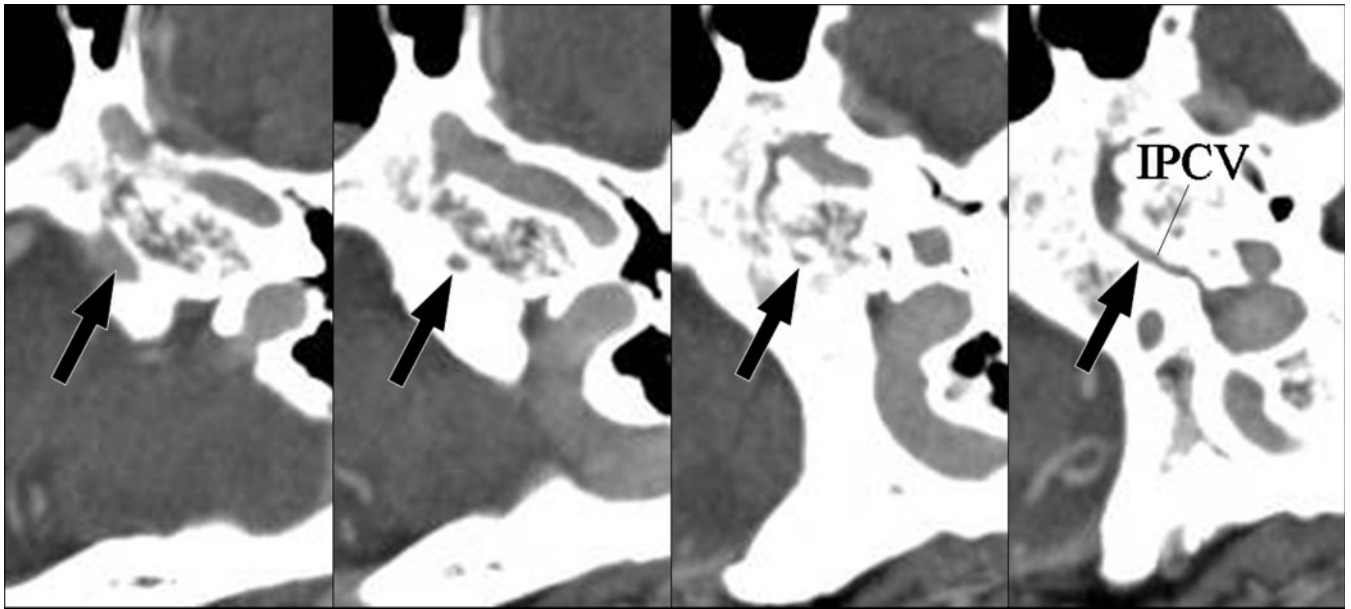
Type B₂ inferior petrosal sinus (IPS). A 79-year-old female with tinnitus. Axial CT images show the left IPS penetrating the petroclival bone and draining into the inferior petroclival vein (arrows).
